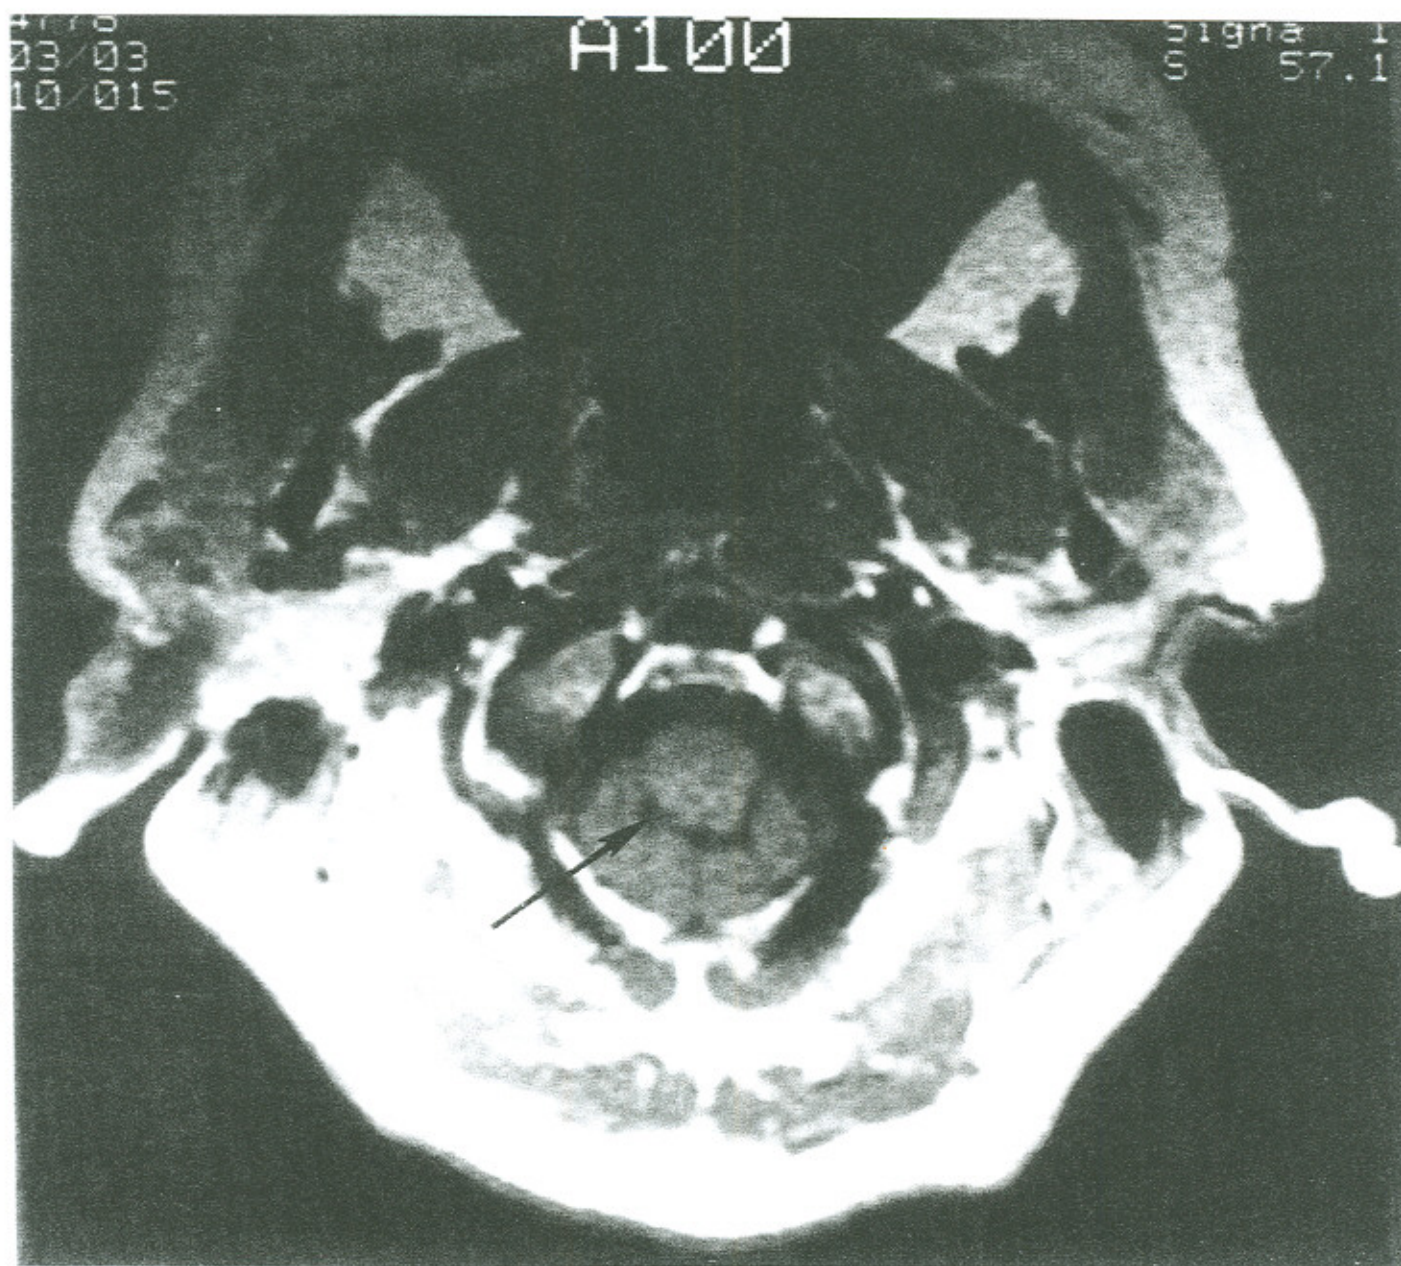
Axial T1 weighted MR image. The medulla is slightly compressed (short arrow) and there is thinning of the cisterna magna (long arrow).
